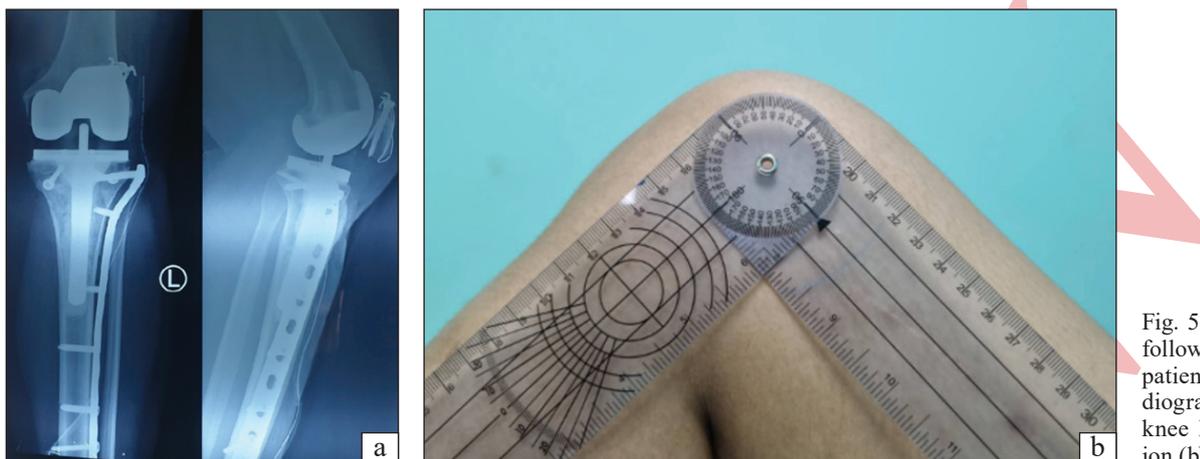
Two-year follow-up of the patient. Knee radiograph (a) and knee ROM flexion (b)
